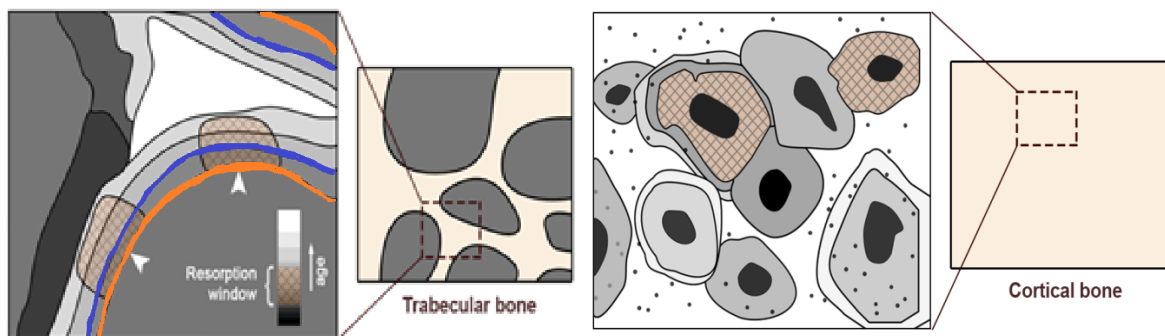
graphic displaying the remodelling regions of bone tissue adapted from Berli et al. (2017), proposed possible thresholds have been added to the trabecular bone image for the Archimedes and CT thresholds at ~1.1 (orange) and ~1.3 (blue) g/cm³ respectively
